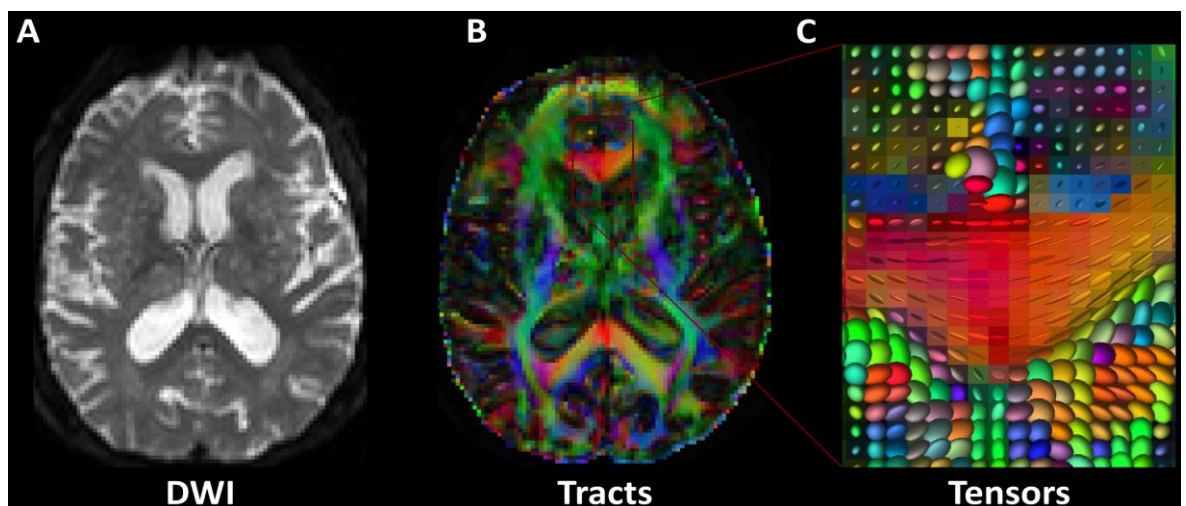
Diffusion Tensor Imaging (DTI). Based on diffusion-weighted imaging (DWI), an initial DWI image (A) can be used to create tracts (B) by estimating tensors (C). Colour-coding of the tensors can reveal the tracts' position, direction (red for right-left, blue for superior-inferior, green for anterior-posterior), and anisotropy (as indicated by the tract's brightness). Tractography methods use tensors to track fibres along their whole length and reveal the gross anatomy of cortical tracts. Images were created using FSLeyes in FSL 5.0.
